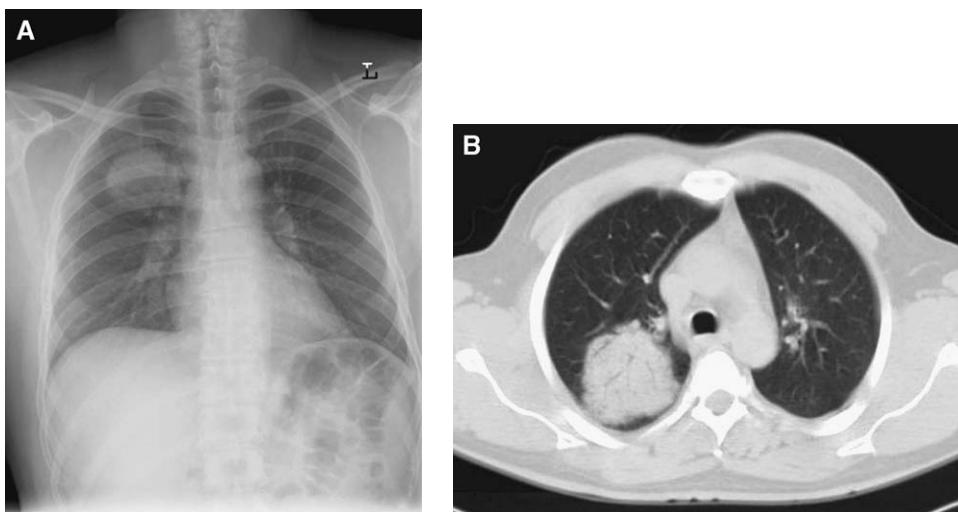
Round pneumonia caused by *S pneumoniae*. (A) PA chest. (B) CT scan.
